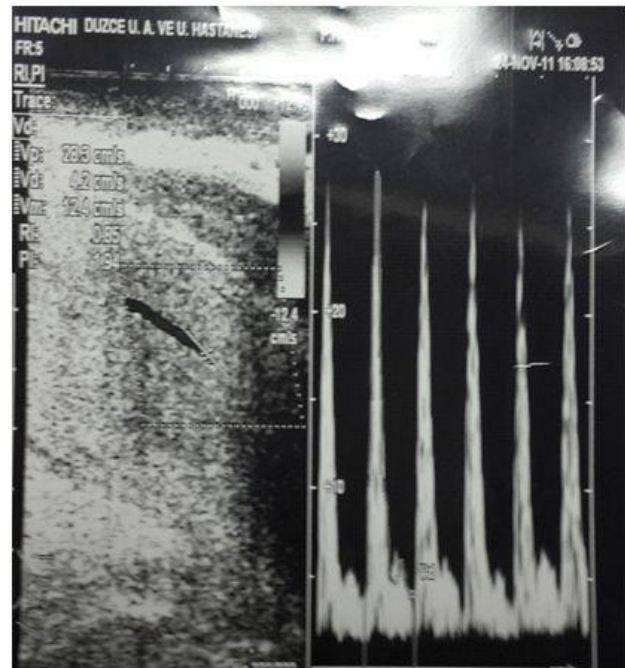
Postoperative penile Duplex Doppler ultrasonography
